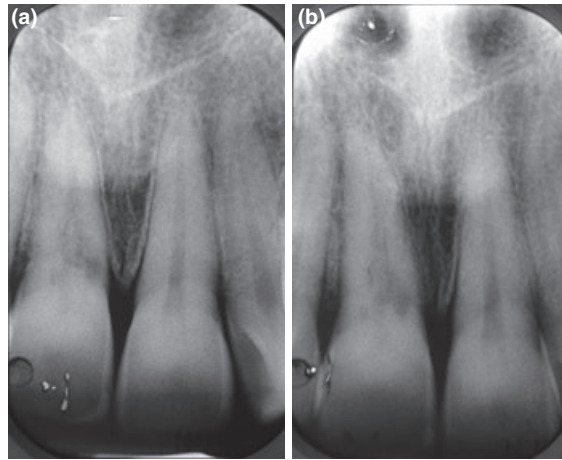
Two periapical radiographs taken at different horizontal angles confirm the resorptive lesion is palatally positioned using the parallax principle. The lesion appears to extend mesally, although this is difficult to confirm.
